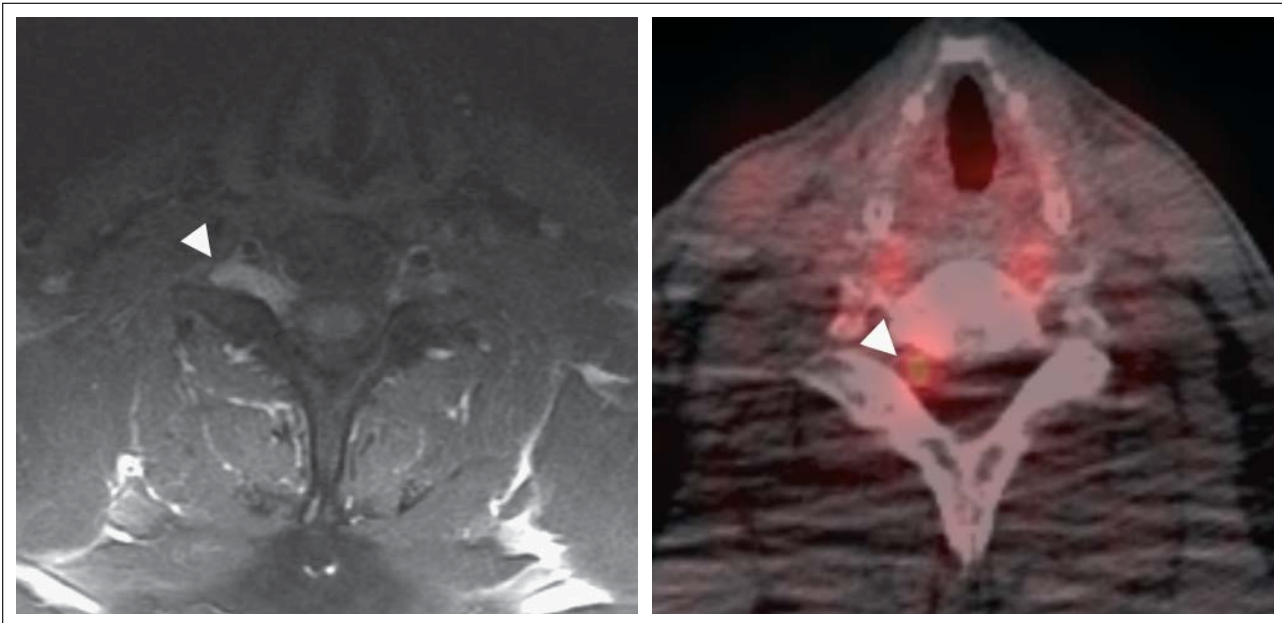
Magnetic resonance imaging shows a thickened and enhancing lower cervical nerve root in a patient with primary neurolymphomatosis [(a) T1-weighted sequence after administration of gadolinium]. 18-Fluorodeoxyglucose positron emission tomography reveals increased tracer uptake within the affected nerve root [(b) arrow head].
